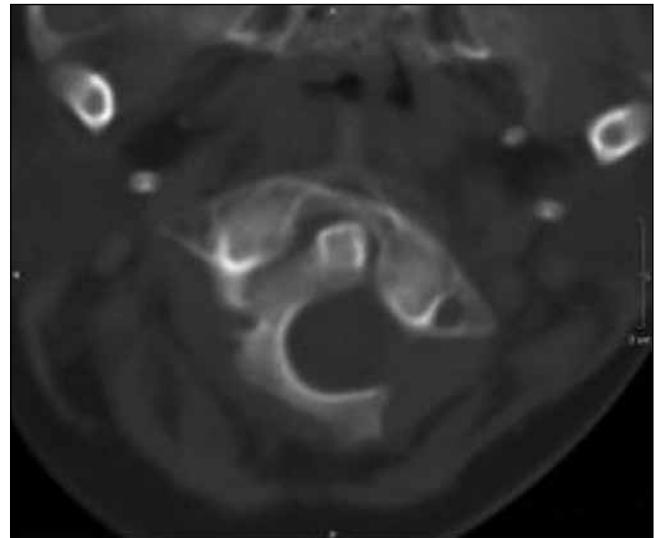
Axial CT scan showing rotatory atlanto-axial subluxation with anterior displacement of atlas (Fielding Type II subluxation).
